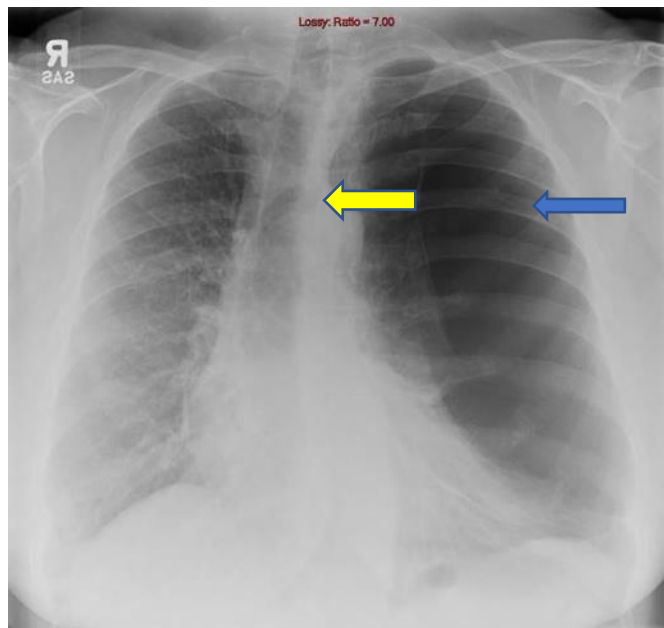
Plain radiograph of a patient at Liverpool Heart and Chest Hospital demonstrating a large bulla in left hemithorax (blue arrow) causing mediastinal shift. (yellow arrow)
